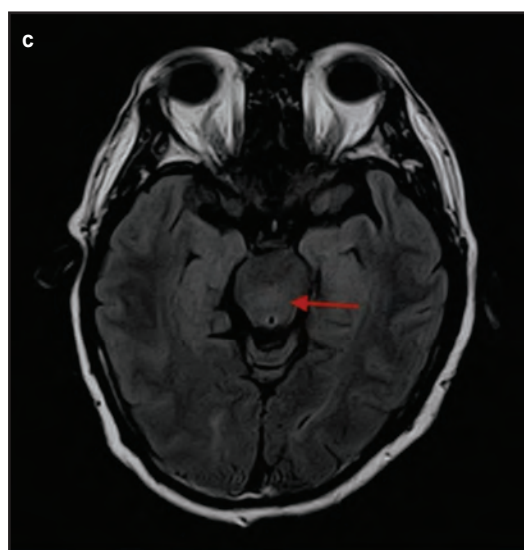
Axial FLAIR sequence depicting the similar hyperintense focus at the central pontine.
